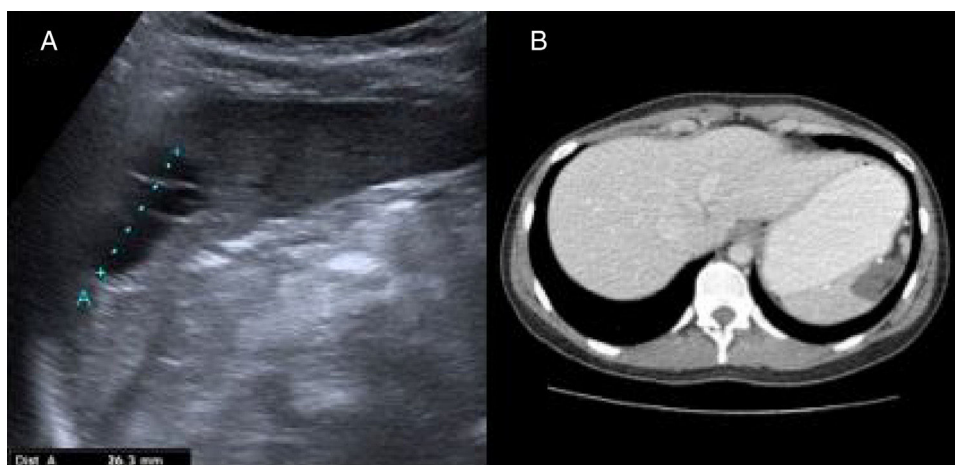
A) Postoperative abdominal ultrasound: a well-defined, anechoic, polylobulated lesion with echogenic internal septa in the interpolar region of the spleen, measuring 32 mm in diameter, consistent with a cystic remnant. B) Computed tomography scan: altered splenic contour with a 22 x 23 mm uniform hypodense lesion consistent with a postoperative cystic remnant.
